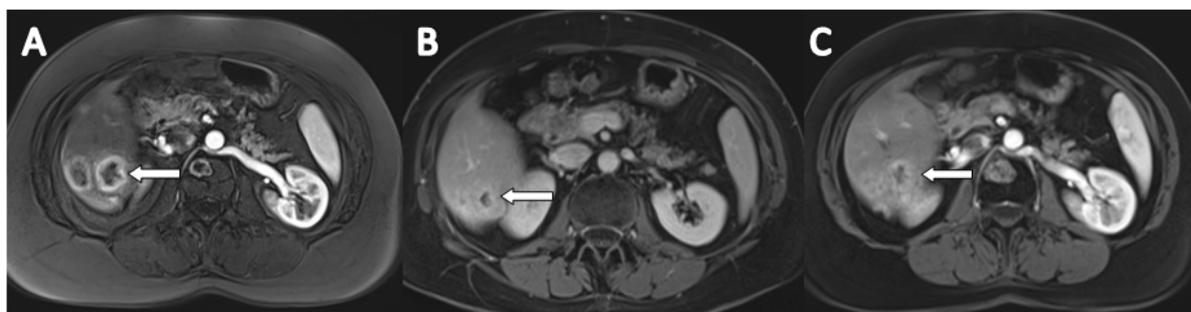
Contrast-enhanced MRI of the liver of patient 5 before (A), 2 months after (B) and 8 months after (C) the second PIHP.
